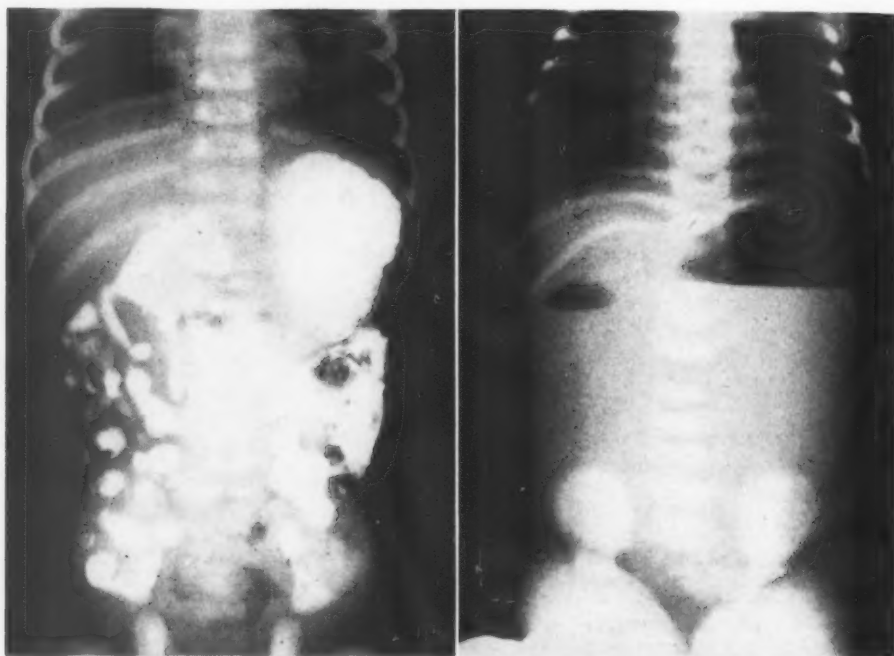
Cases 37 and 38. These two roentgenograms show the extremes of findings in cases of malrotation with volvulus. Case 37 on the left, who was operated upon at six days of age, shows considerable barium in the small intestine as well as dilated stomach and duodenum. Case 38 on the right was operated upon at two days of age, and on the plain roentgenogram shows the two large gas bubbles and fluid levels characteristic of duodenal obstruction, but no gas in the intestine. Both recovered.
